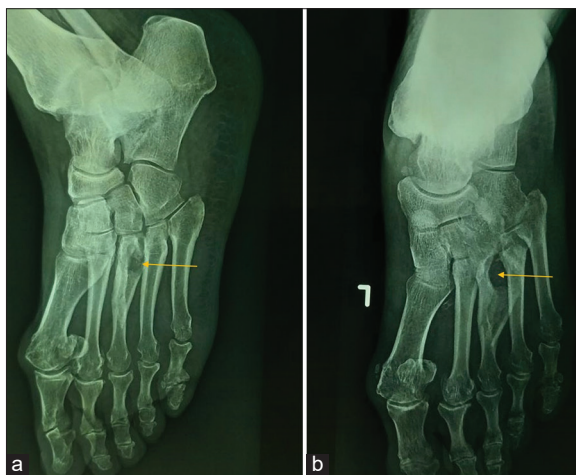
Follow-up plain radiograph at 1 year showing the anterior-posterior (a) and oblique view (b) with no evidence of recurrence
